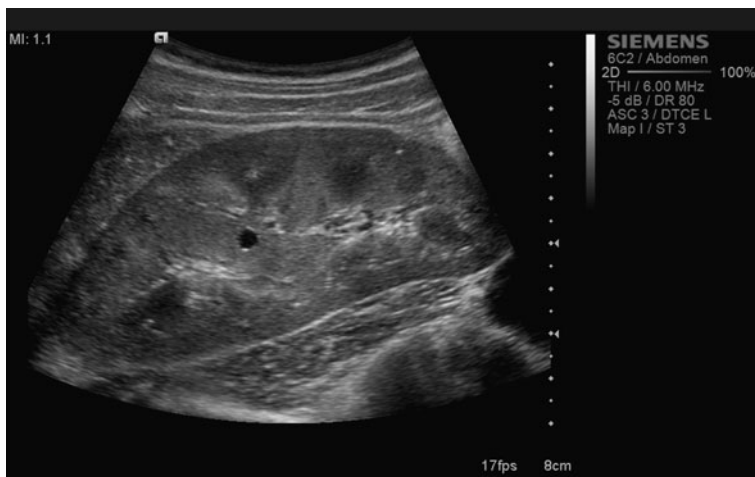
Ultrasound B-scan of the abdomen (image with kind permission of Siemens Sector Healthcare, Erlangen, Germany)
